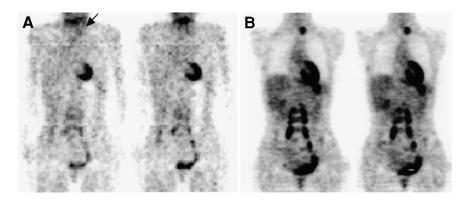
Patient 4. Coronal images obtained by FDG hybrid PET (A) and dedicated PET (B). Left supraclavicular site is clearly depicted by dedicated PET. Hybrid PET, on other hand, shows only faint uptake at corresponding site (arrow), which is not considered pathologic.
